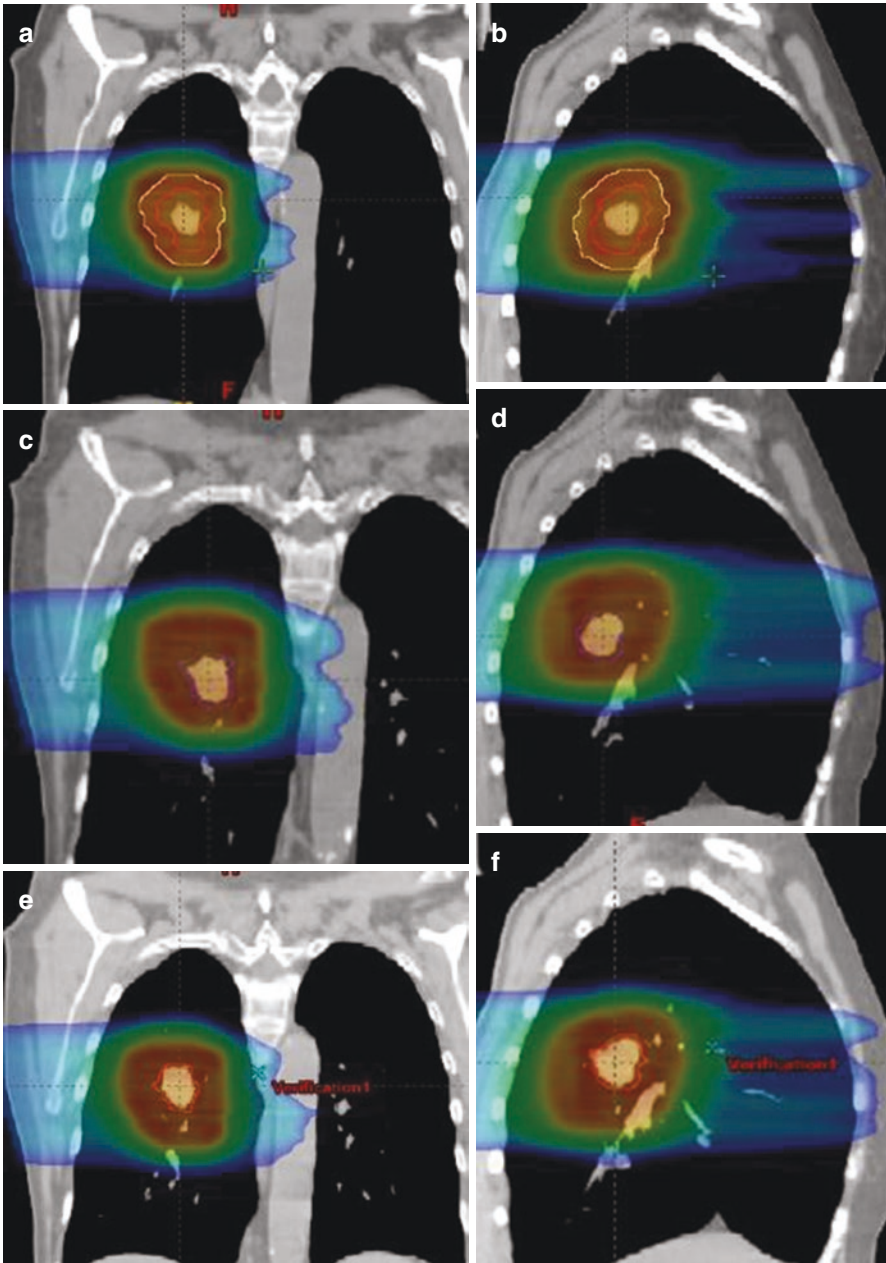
Dose distributions calculated on average CT (a, b), (a) average CT, frontal, and (b) average CT, sagittal; end-inhalation CT (c, d), (c) end of inhalation, frontal, and (d) end of inhalation, sagittal; and end-exhalation CT (e, f) with identical beamline, (e) end of exhalation, frontal, and (f) end of exhalation, sagittal
